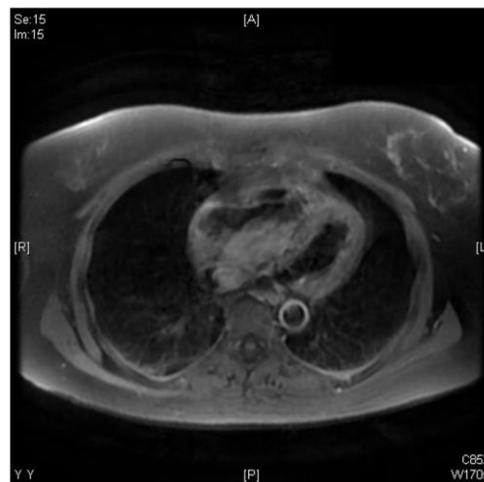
Cardiac magnetic resonance imaging shows intracardiac mass with gadolinium uptake, favouring mass over thrombus.
